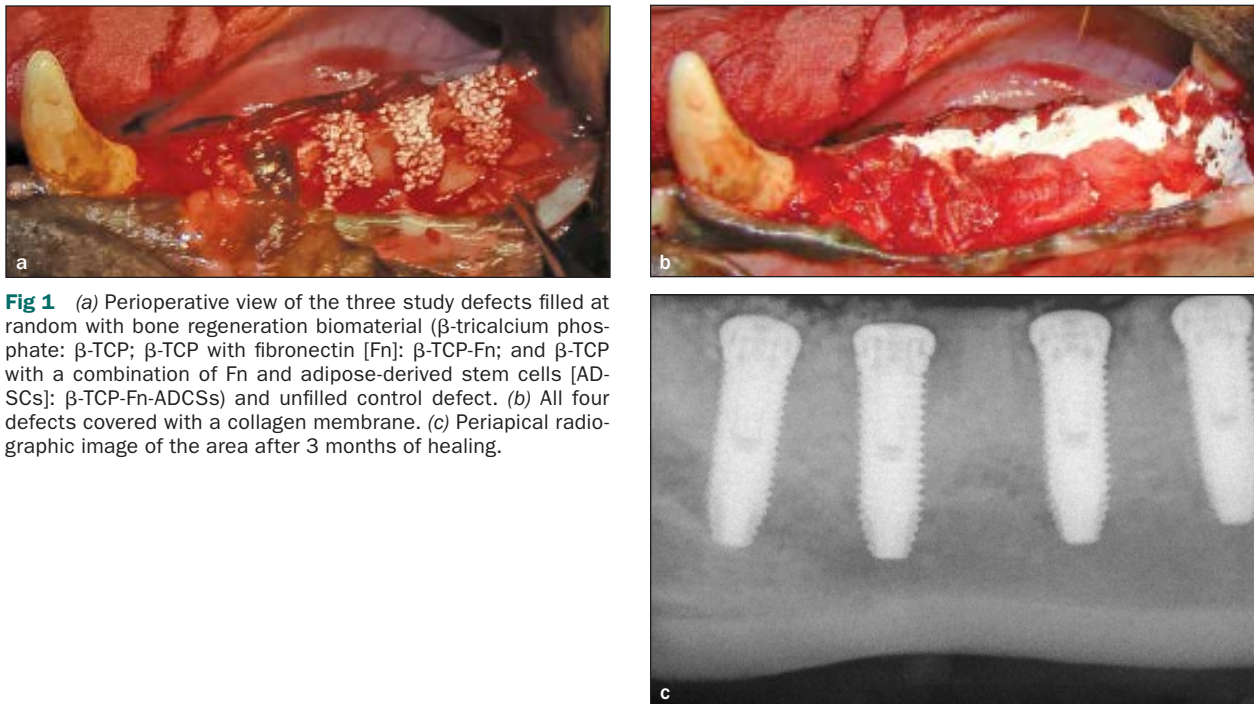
(a) Perioperative view of the three study defects filled at random with bone regeneration biomaterial (β -tricalcium phosphate: β -TCP; β -TCP with fibronectin [Fn]: β -TCP-Fn; and β -TCP with a combination of Fn and adipose-derived stem cells [ADSCs]: β -TCP-Fn-ADCSs) and unfilled control defect. (b) All four defects covered with a collagen membrane. (c) Periapical radiographic image of the area after 3 months of healing.
